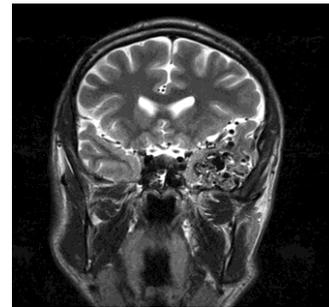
Coronal MRI T2 weighted image shows AVM in the left cerebral hemisphere
